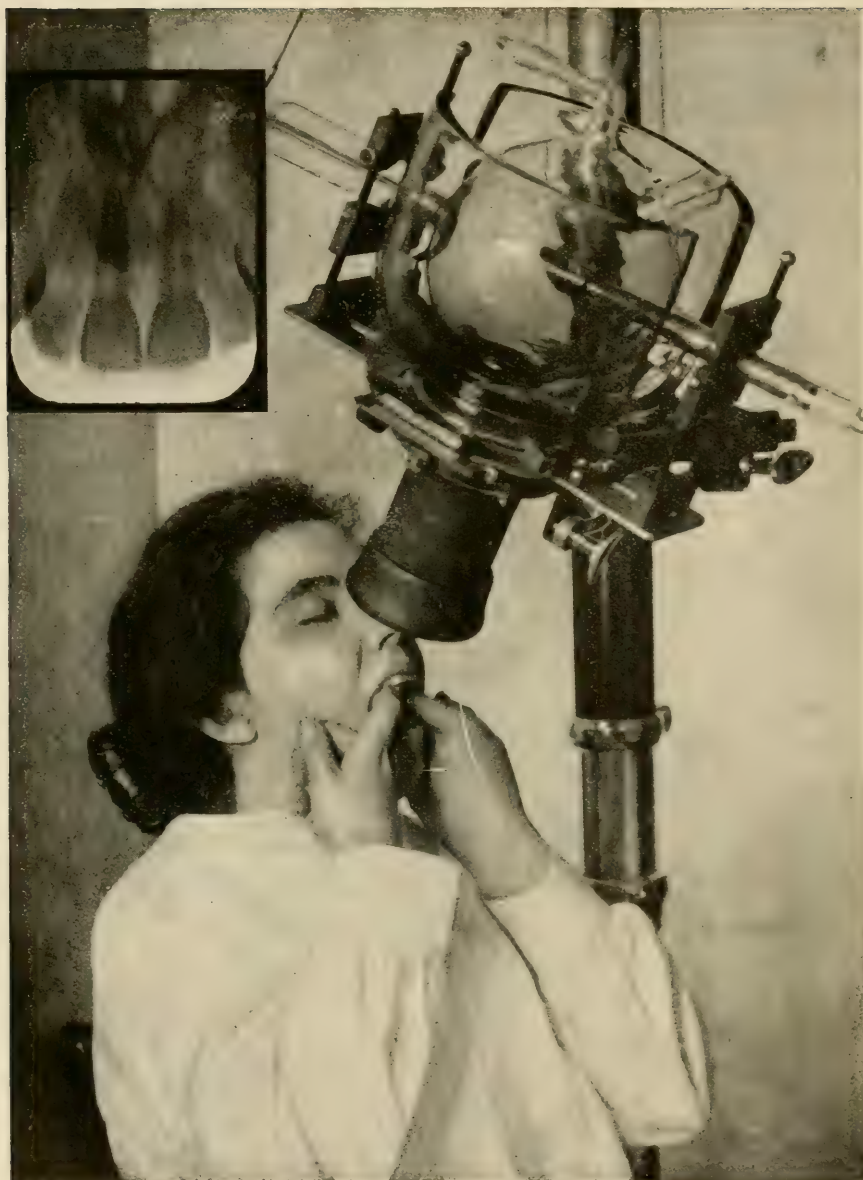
Correct pose for radiographing upper anterior teeth with film in the mouth as in Fig. 93. Radiograph made from this pose. (It took the writer a long time to learn that, when radiographing upper anterior teeth, it is best to try to radiograph only two teeth at a time, to bend a part of the film deliberately in order to avoid bending all of it (Fig. 101) and to have the patient hold it with the thumb, not the fingers or finger.)
